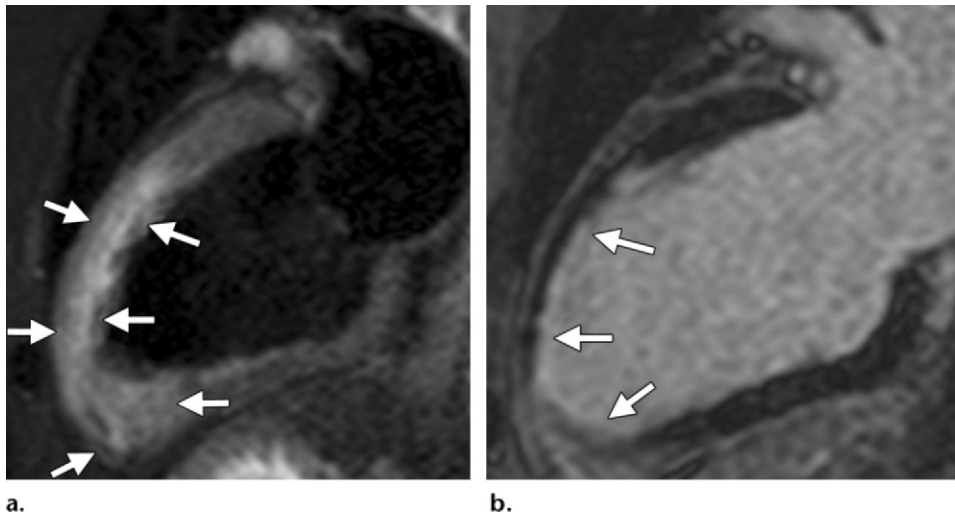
MR imaging findings in acute MI in a 34-year-old man with sudden onset of chest pain, elevated cardiac enzymes, and ST-segment elevation. (a) Two-chamber T2-weighted short-inversion-time inversion-recovery (STIR) image shows high-signal-intensity edema in the mid and apical anterior wall (arrows), consistent with myocardial edema. (b) Two-chamber delayed-enhancement image shows subendocardial scarring in the mid to apical anterior wall (arrows), which is less extensive than the edema seen in a; the difference between the two areas defines the myocardial “area at risk” without subsequent revascularization.
